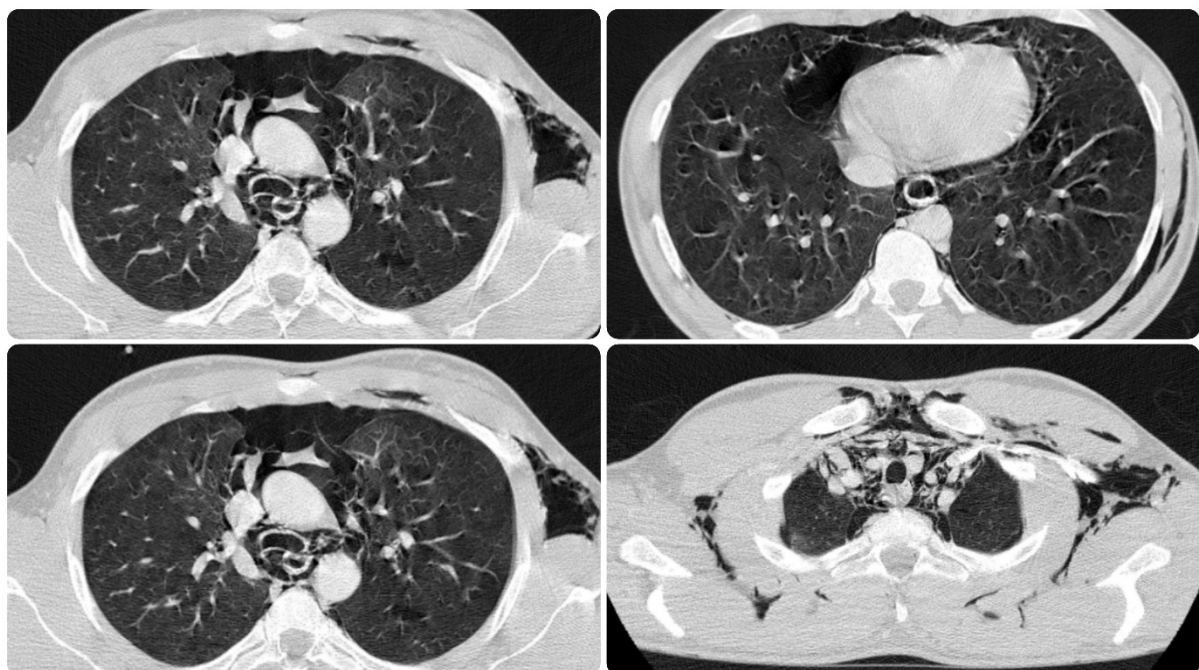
chest computed tomography (CT) indicates pneumomediastinum and subcutaneous emphysema without any obvious lung parenchymal involvement
